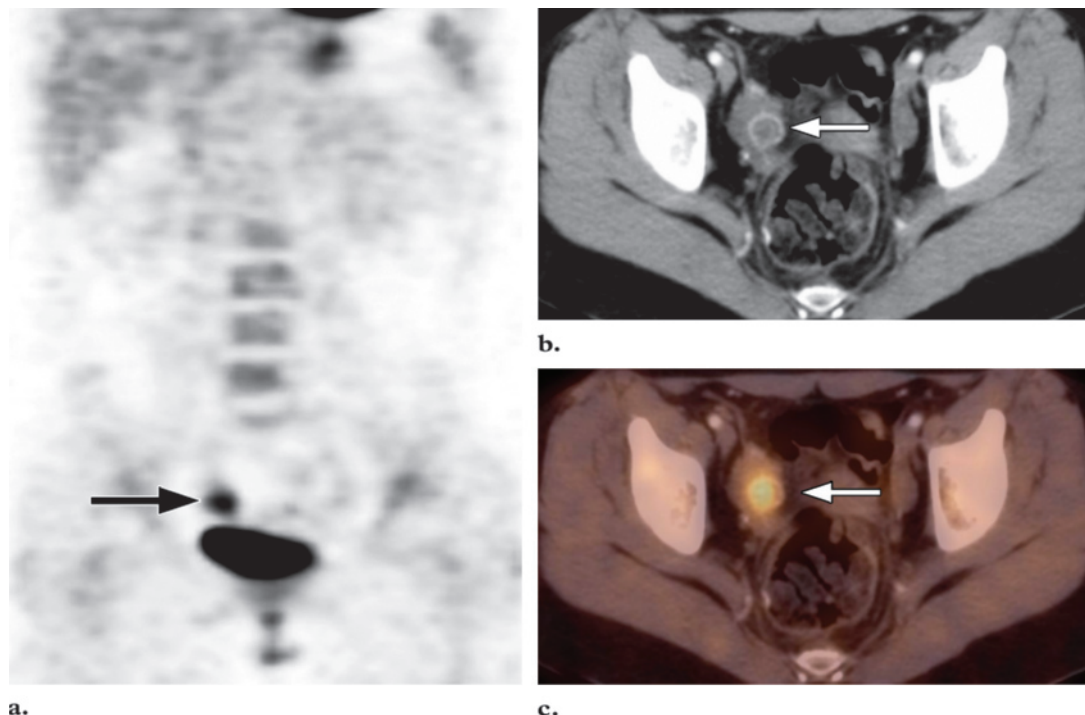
Ovarian corpus luteum cyst in a 17-year-old girl with a history of stage IVB Hodgkin disease. The patient's most recent menstrual period occurred 3 weeks prior to her undergoing follow-up ^{18}F FDG PET/CT after having completed chemotherapy. (a) Coronal FDG PET scan shows focal increased uptake in the right side of the pelvis (arrow). (b) Transverse CT scan shows a cystic structure with rim enhancement in the right ovary (arrow), a finding that is consistent with an ovarian corpus luteum cyst. (c) Transverse fused PET/CT image shows focal increased uptake in the cyst (arrow).
